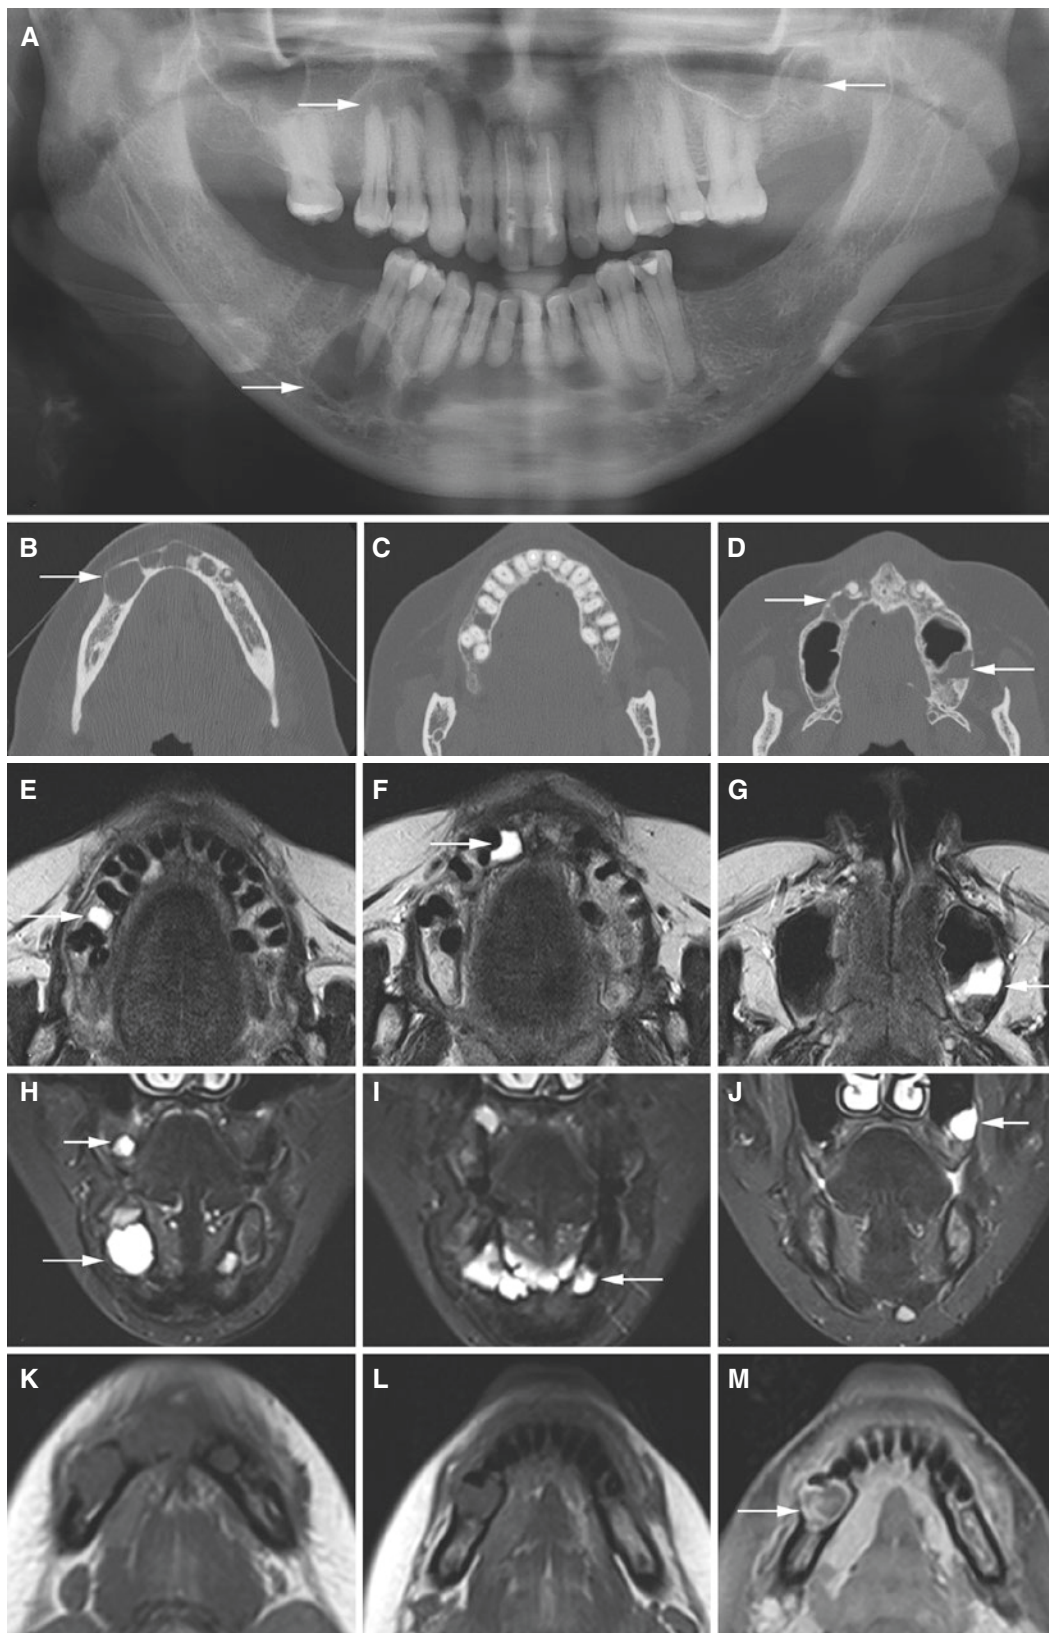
Florid osseous dysplasia, mandible and maxilla; 45-year-old female with some pain from the second premolar in the left mandible. (A) Panoramic view shows radiolucent areas both in the mandible and in the maxilla (arrows). (B, C, D) Axial CT images confirm radiolucent areas in the mandible and maxilla (arrows). (E, F, G) Axial T2-weighted
